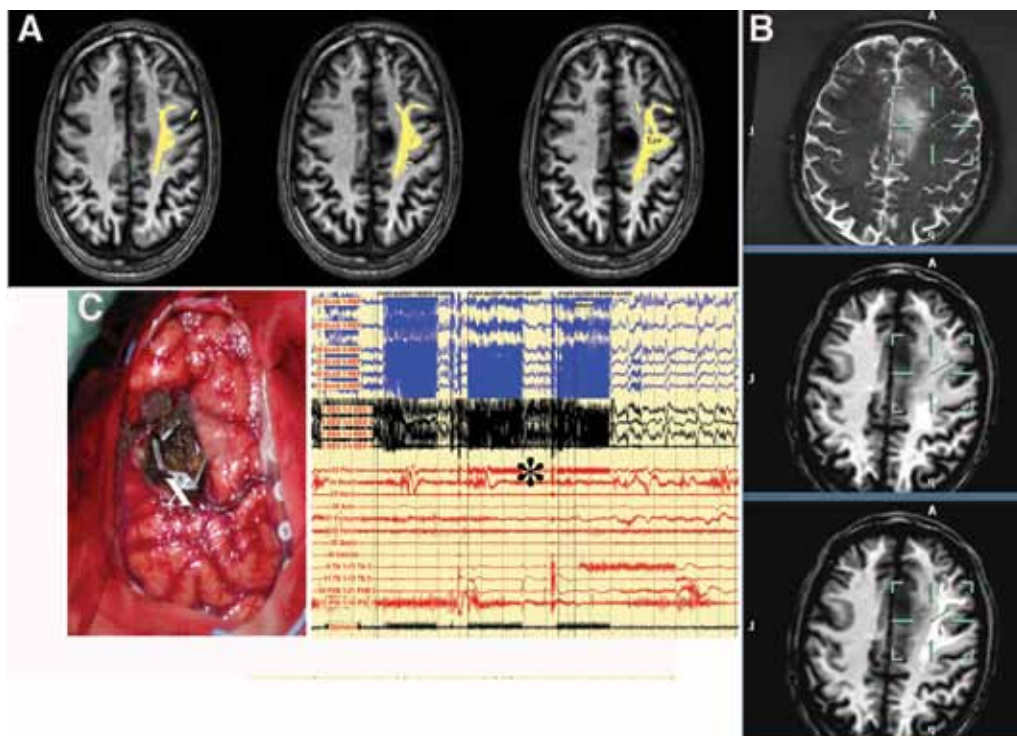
Diffusion tensor imaging–FT reconstruction of the face premotor fibers. A: A case of a left-hemisphere oligodendroglioma in which DT imaging–FT reconstruction of the face premotor fibers (yellow ROIs) was merged with T1-weighted MR images. The fibers were located at the lateral border of the tumor. B: A similar case of a left-hemisphere oligodendroglioma, in which DES, performed at the center of the green cursors, located the fibers intraoperatively, in the same position as depicted by DT imaging–FT as white ROIs (lower panel). The middle panel shows the DT imaging–FT reconstruction of the CST. C: The left panel is an intraoperative picture of the surgical field. The white X indicates the position of the fibers at the posterior border of the surgical cavity. The right panel reports the EMG findings. The black asterisk indicates the activation of the upper and lower lips, which resulted in speech arrest (anarthria).
